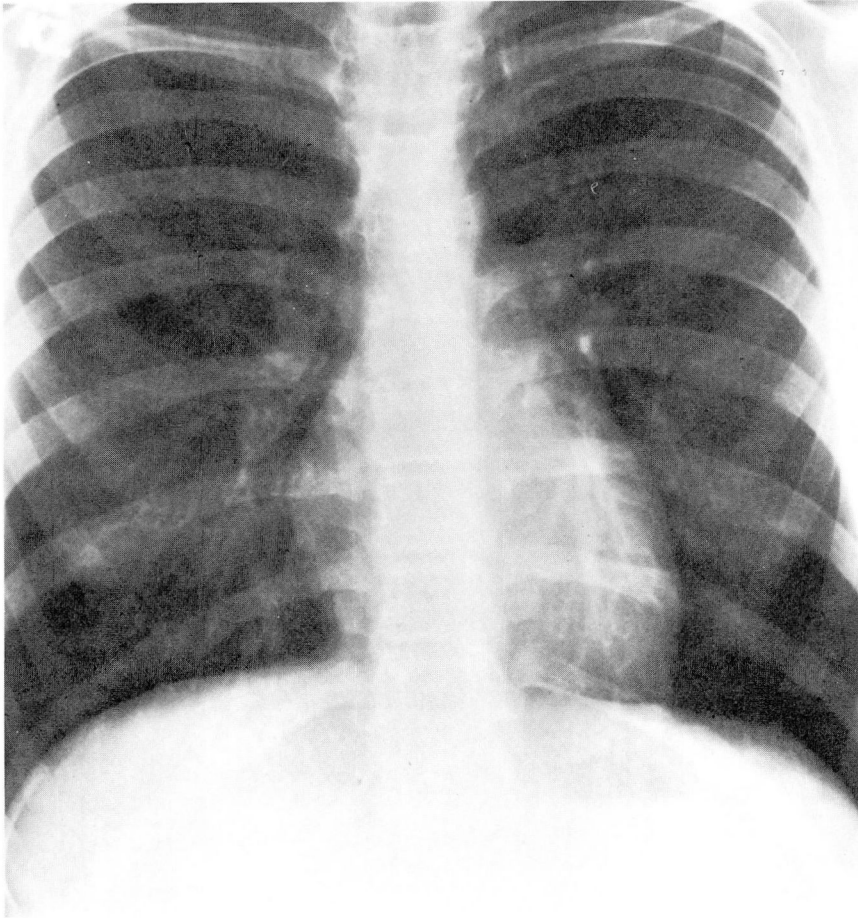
Preoperative chest roentgenogram before excision of an anomalous right ventricular outflow tract muscle bundle.
